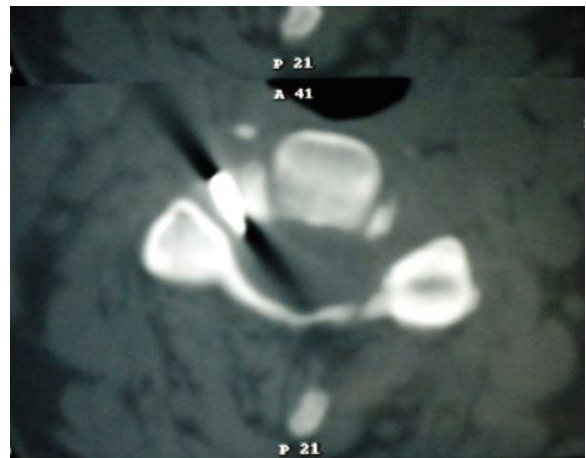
A cervical spine computed tomography showed a foreign body lying across the C3-4 intervertebral foramen
